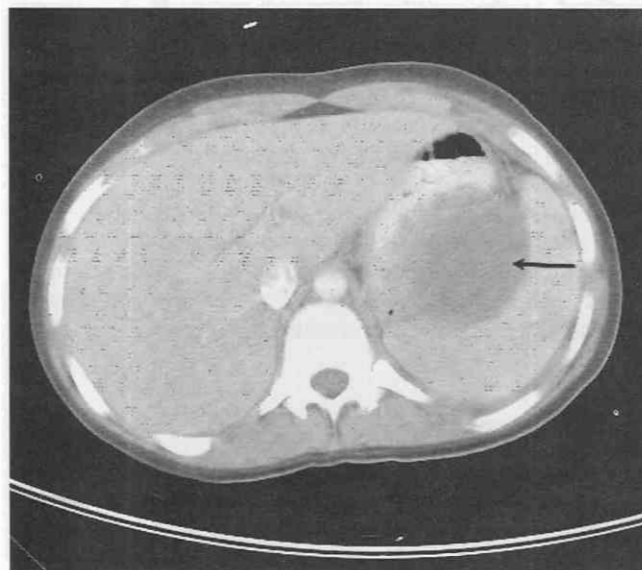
Abscess in a patient lying in the supine position. CT scan shows a large abscess (arrow) in the splenic recess of the lesser sac, which is effacing the stomach anteriorly.
